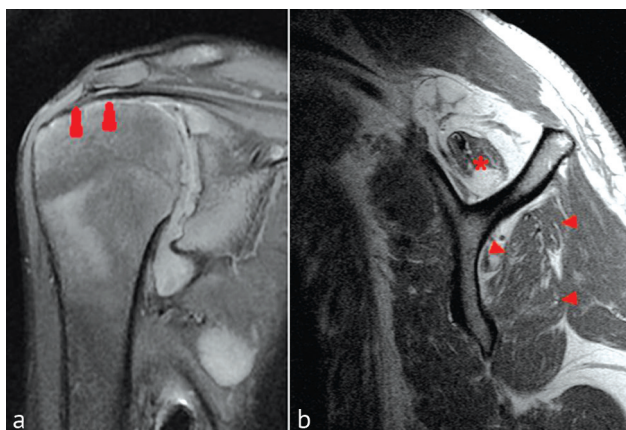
MRI images of the shoulder joint of a 64-year-old patient M. showing a anteroposterior b sagittal views
